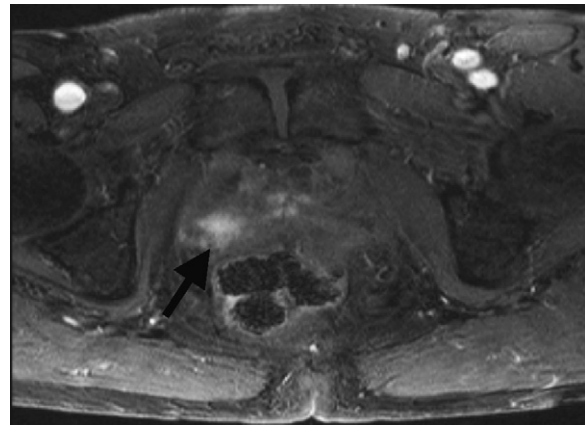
Dynamic contrast enhanced MRI in T1 weighted image shows an early enhancement (arrow) in the right peripheral zone a minute after gadolinium contrast injection.
